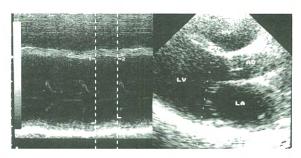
Echocardiography shows severe left atrial and left ventricular dilatation and left ventricular systolic dysfunction. LV: Left Ventricle, LA: Left Atrium
